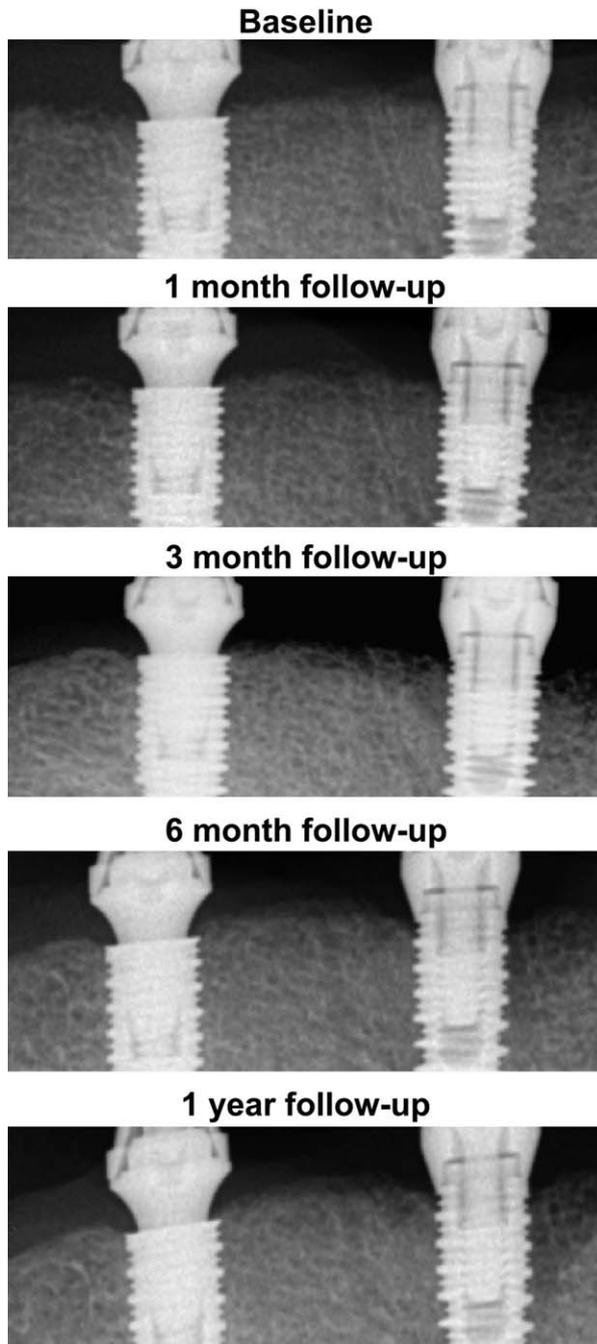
Representative radiographic evaluation of periimplant bone loss for MT (left implant) and EH (right implant), at all evaluated follow-up times.
